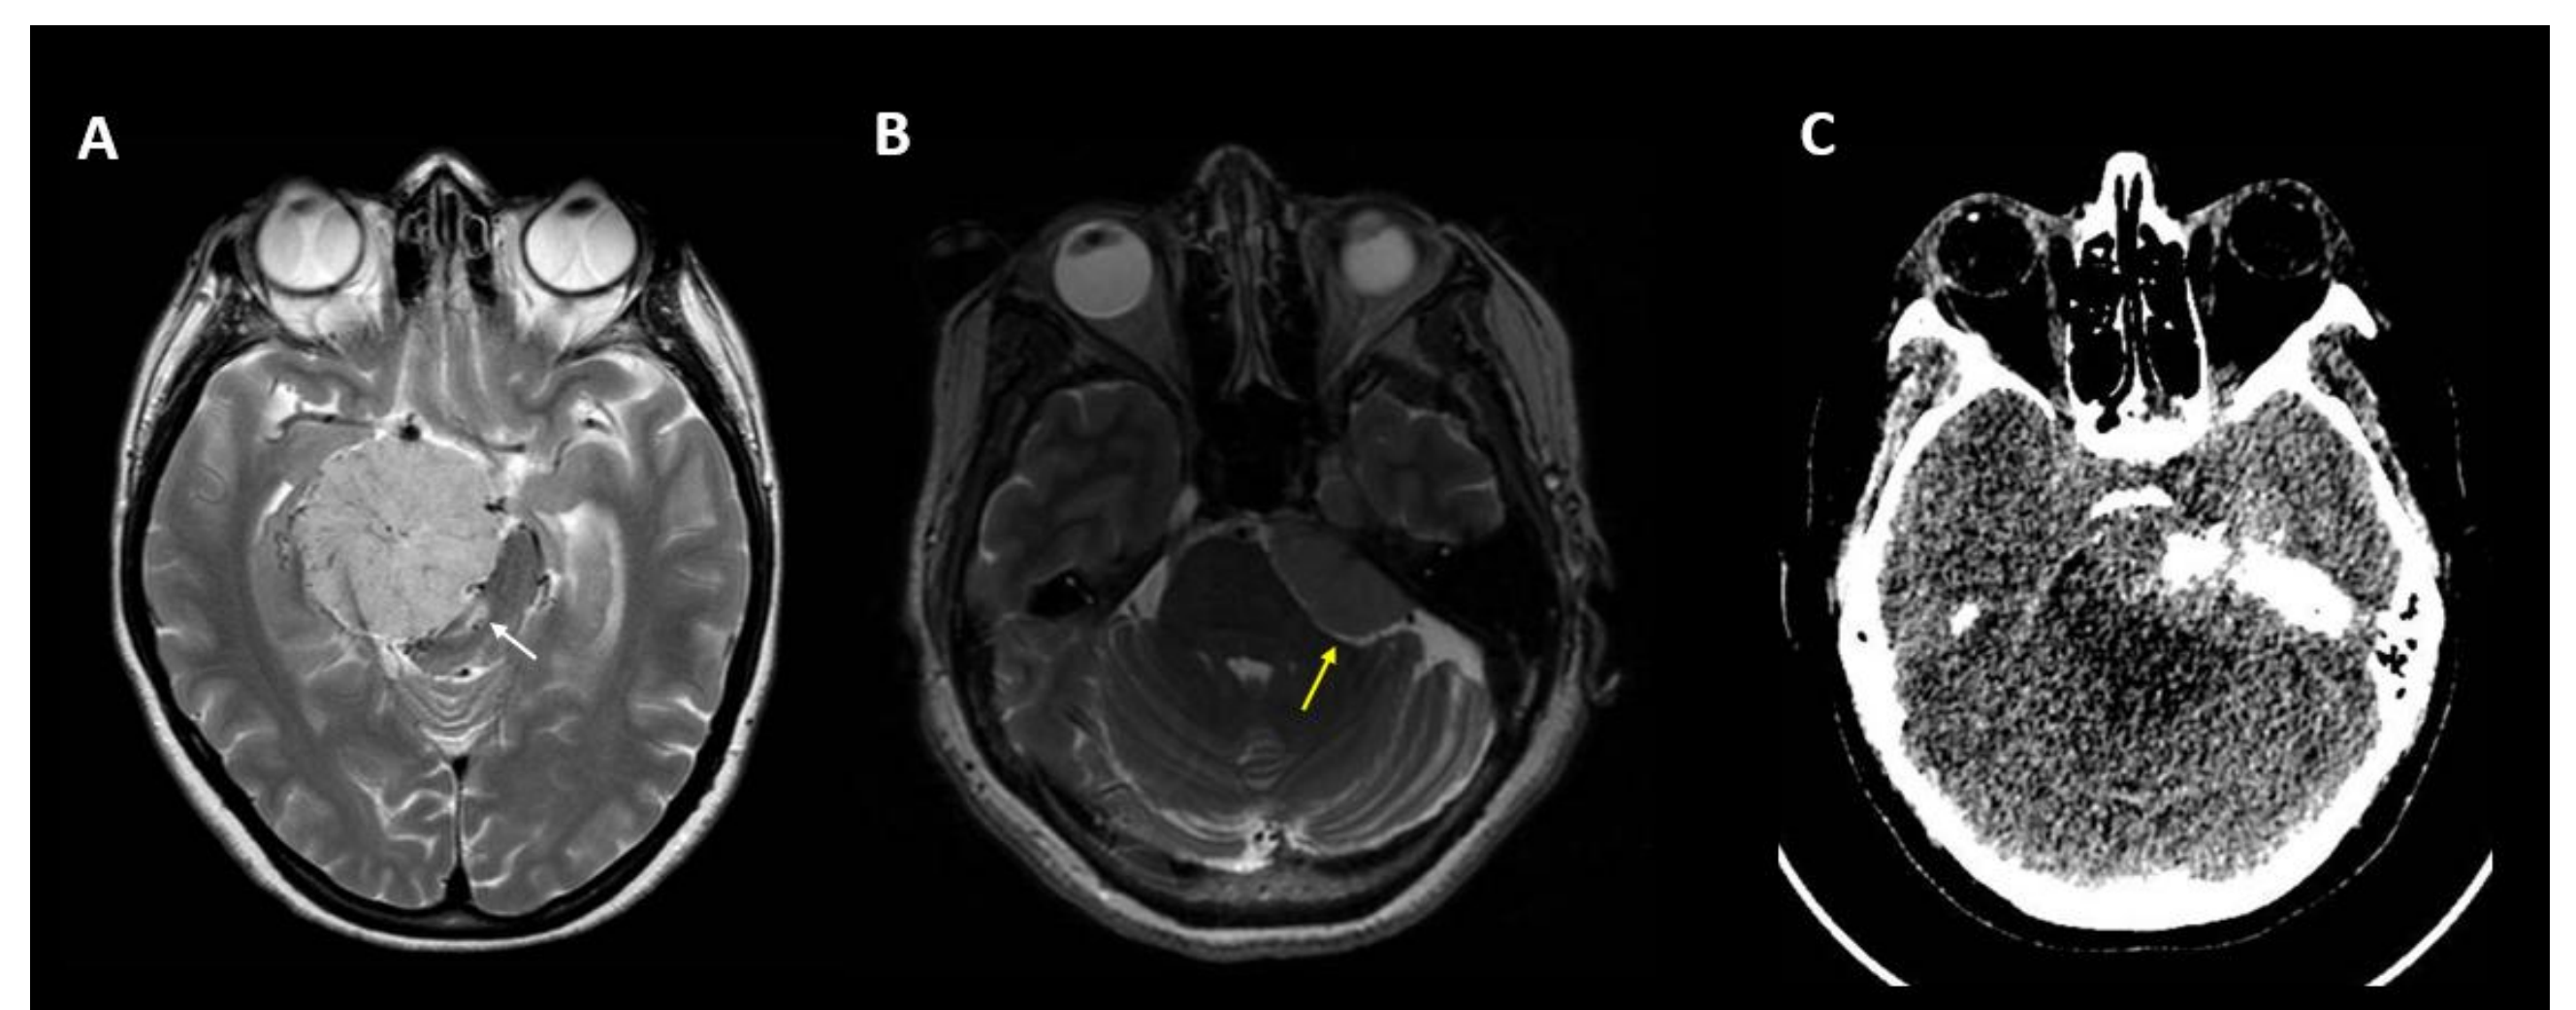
T2 weighted MRI (A and B) depicting well defined tumor cleft (B yellow arrow) and loss of it with brainstem edema (A white arrow). Figure C demonstrates tumor calcifications. Brainstem compression was seen in 92.45% of cases with edema in 18.8%. Calcifications were noticed in 16.98% of tumors.
